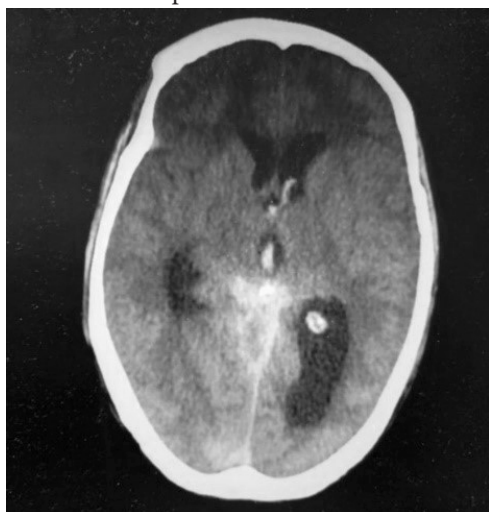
Cranial CT scan of the patient
